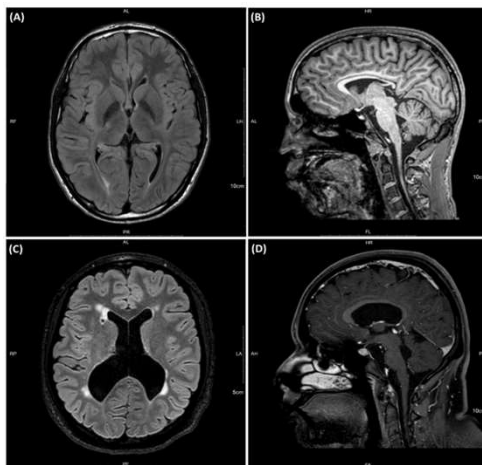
Brain MRI of the patient [T2-weighted axial view (A), T1-weighted sagittal view (B)] shows diffuse cerebral and cerebellar atrophy, with thinning of the corpus callosum. Brain MRI of the sibling [T2-weighted axial view (C), T1-weighted sagittal view (D)] shows diffuse cerebral and cerebellar atrophy, with ventriculomegaly.
